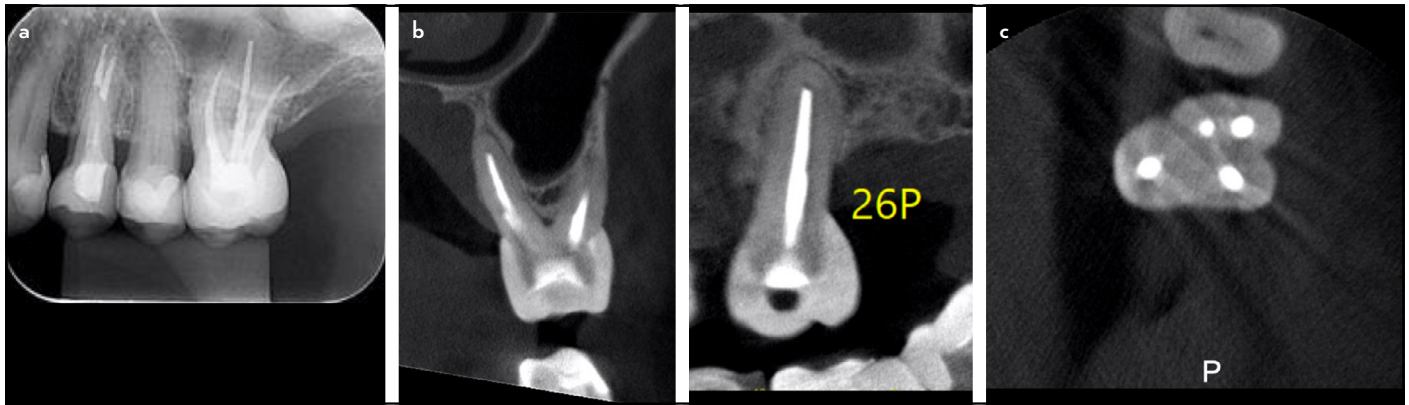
Twelve-year follow up. (a) Periapical radiograph showing apical repair and maintenance of the coronal restoration in the maxillary left first molar; (b) Coronal and sagittal views showing apical healing of the palatal root; (c) Axial section confirming the presence of the four previously filled canals.
